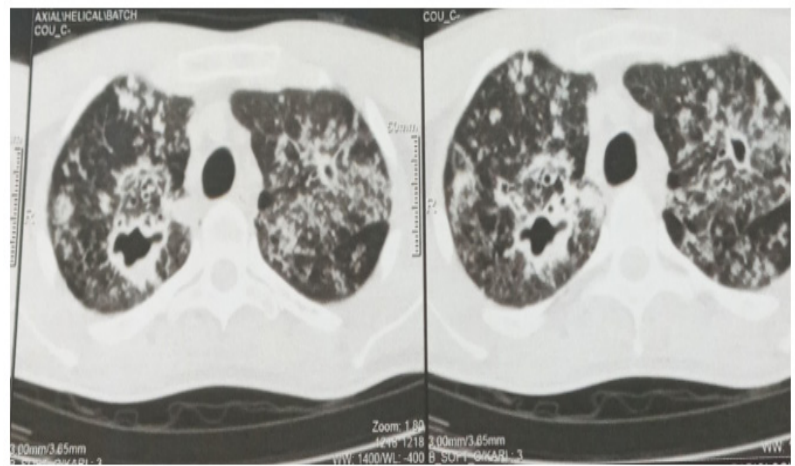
bilateral diffuse confluent nodules and micronodules in favor of tubercular miliary (Cervico-thoracic CT scan at the thoracic level)
